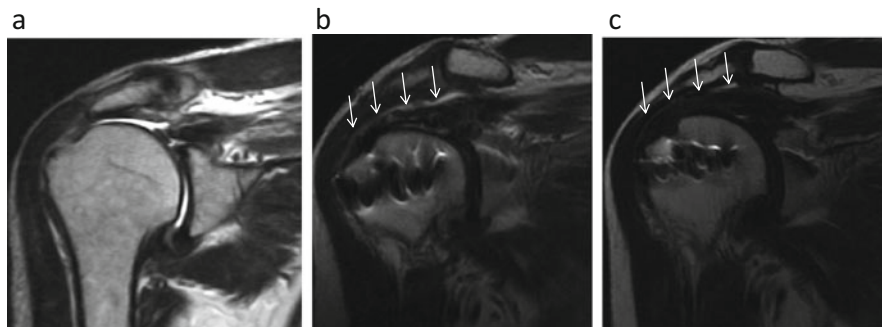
MRI findings before and after superior capsule reconstruction. (a) Before surgery. The torn supraspinatus tendon was severely retracted, and the supraspinatus muscle was severely atrophied and infiltrated with fat. (b) One year after surgery. (c) Four years after surgery. The reconstructed superior capsule has become thicker (*white arrows*)
